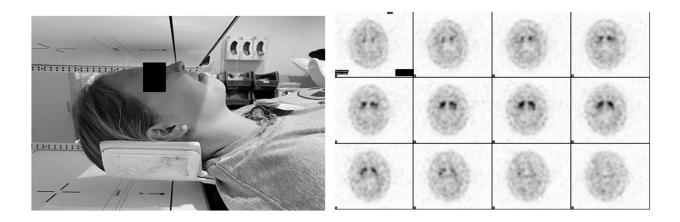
1a. Correct position with the head resting in the head and neck holder and the chin in neutral position. 1b. Normal axial brain SPECT without head tilt.
